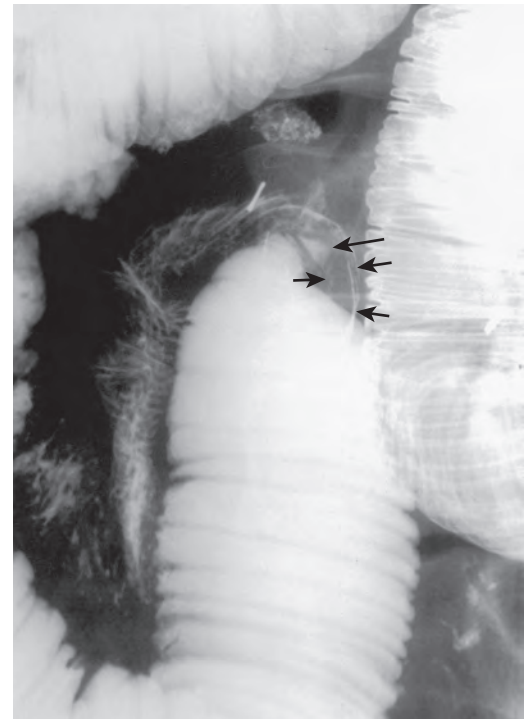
Circumferential adhesive band. Spot radiograph from enteroclysis shows abrupt angulation (long arrow) at the transition zone. The bowel just distal to the angulation is tight (short arrows), but folds are preserved throughout the region. (Courtesy Hans Herlinger, MD.)
